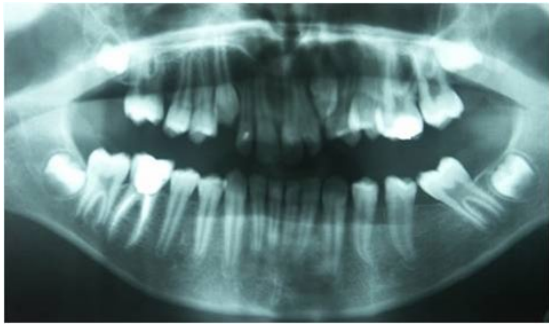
Orthopantomogram showing the tilting of teeth around the extraction site of tooth 36.
